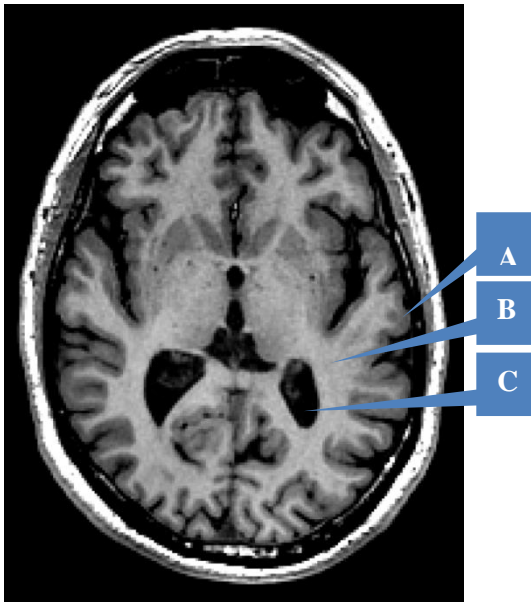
Transverse T1-weighted spoiled gradient recalled echo (SPGR) MRI demonstrating the excellent contrast between different brain tissues: (A) grey matter, (B) white matter, and (C) the cerebrospinal fluid.
